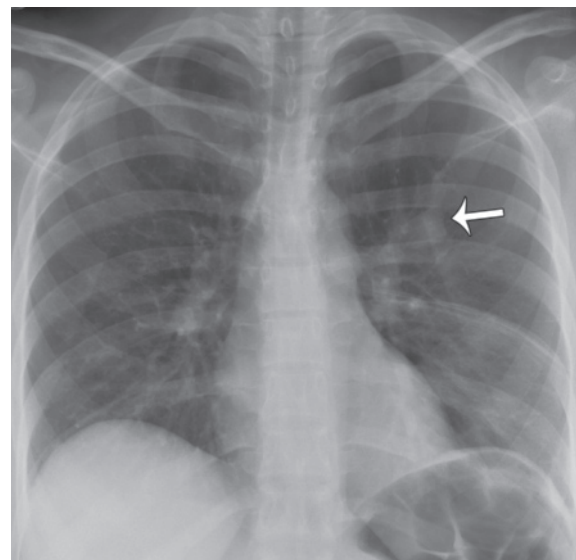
Radiograph shows a branching tubular area of increased opacity (arrow), which represents a bronchocele and extends from the left hilum into the left upper lobe. A thoracostomy tube was placed to treat a left-sided pneumothorax.
